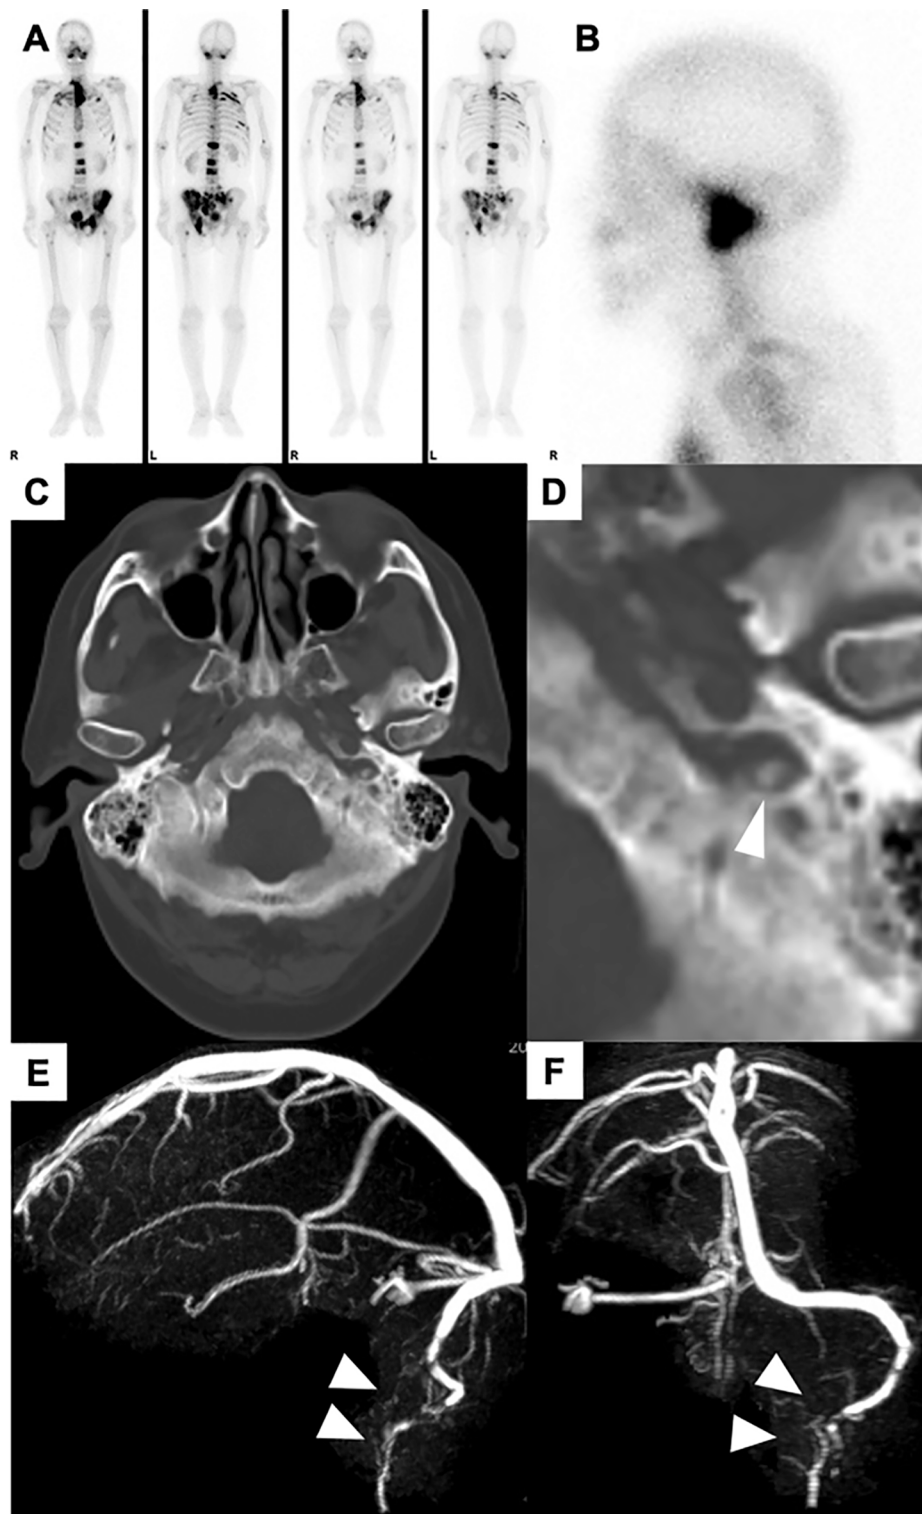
Preoperative bone scintigraphy, computed tomography (CT), and magnetic resonance venography (MRV). (A) Bone scintigraphy revealed multiple bone metastases including the skull base. (B) Head bone scintigraphy with higher magnification. (C) Axial CT image in the bone window demonstrated an osteoblastic mass in the jugular foramen and obscured bone cortex of the posterior cranial fossa. (D) Axial CT image in the bone window with higher magnification. (E: left to right, F: anteroposterior) MRV showed left internal jugular vein stenosis and hypoplasia of the right transverse sinus.
